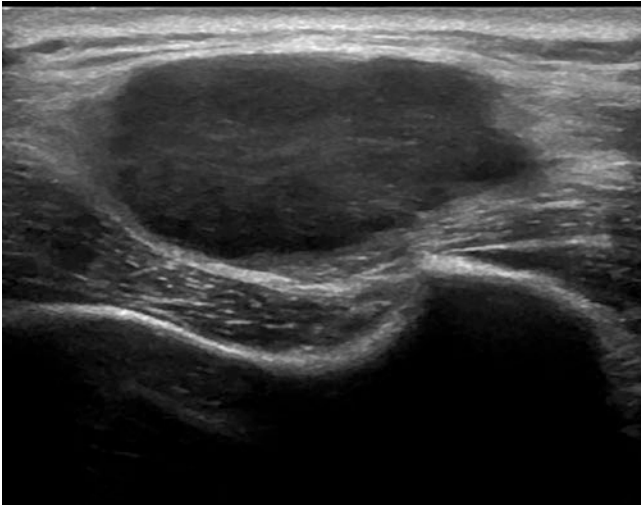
Soft tissue metastasis of a squamous cell carcinoma. On ultrasound the metastasis is seen as a hypoechoic space-occupying lesion with partly sharp and partly blurred margins
